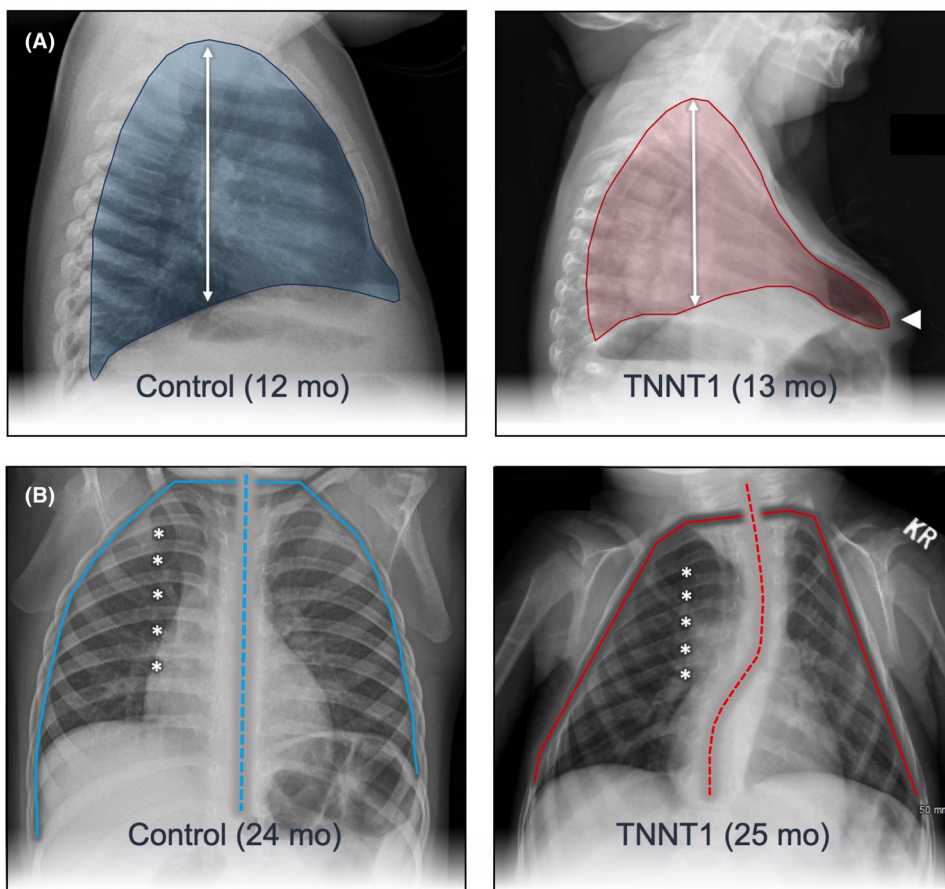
Biomarkers: Chest deformity and blood gases. (A) Lateral chest radiograph of a child with TNNT1 myopathy (*right panel*, age 12 months) compared to a healthy child (*left panel*, age 13 months) shows pectus carinatum (white arrowhead) and cephalocaudal shortening of the thoracic cavity (white arrows). (B) Posterior–anterior chest radiograph at an older age (*right panel*, 25 months) shows contracture of the intercostal spaces (asterisks), flattening of the thoracic contour (solid lines), and scoliosis (dashed line). (C) These anatomical changes were accompanied by progressive hypoxemia and hypercarbia in the months preceding death (asterisks).
